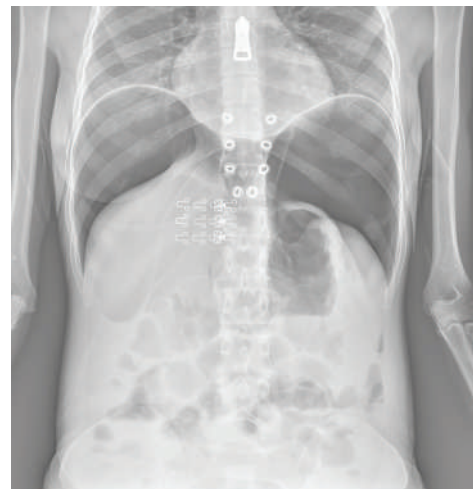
Standing abdominal X-ray.
